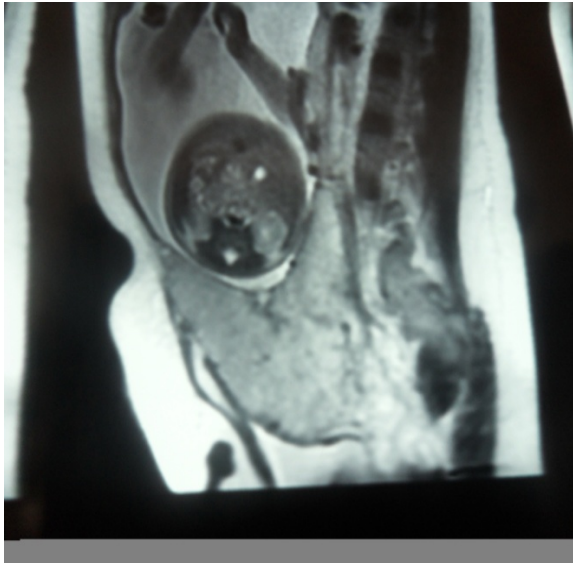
Non-contrast MRI, complete type placenta previa at 33 gestational week.
